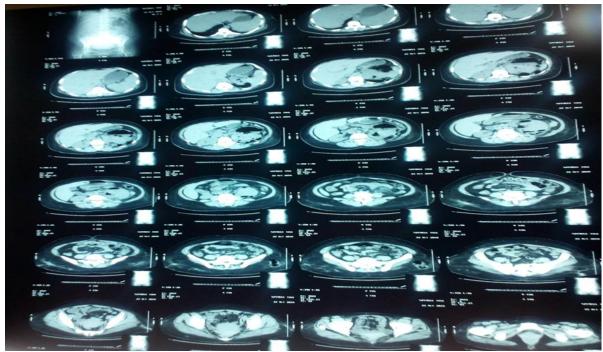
Transverse abdominal CT view showing gas shadows within left renal parenchyma.
